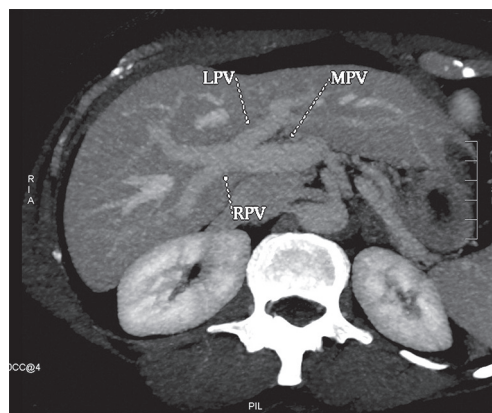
Axial oblique image of a portal venous phase CT demonstrating a trifurcation of the main portal vein (MPV) into the left portal vein (LPV) and the two branches of the right portal vein (RPV), the anterior and posterior right portal veins.
